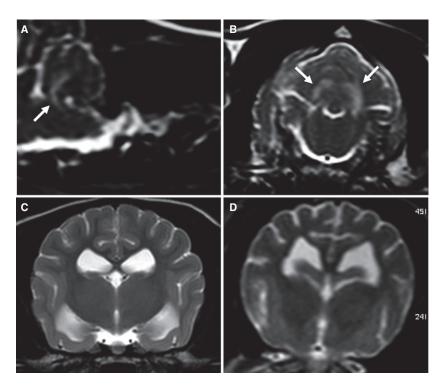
MRI studies at the time of initial presentation (C) and 15 months later (A, B and D). (A) T2-weighted sagittal image at the level of the cerebellum discloses hyperintensity of the caudal cerebellar peduncle (white arrow). (B) T2-weighted transverse image at the level of the cerebellum discloses bilateral hyperintensity of the caudal cerebellar peduncles (white arrows). (D) T2-weighted transverse image at the level of the forebrain discloses widened sulci compared with the initial (C) study.
